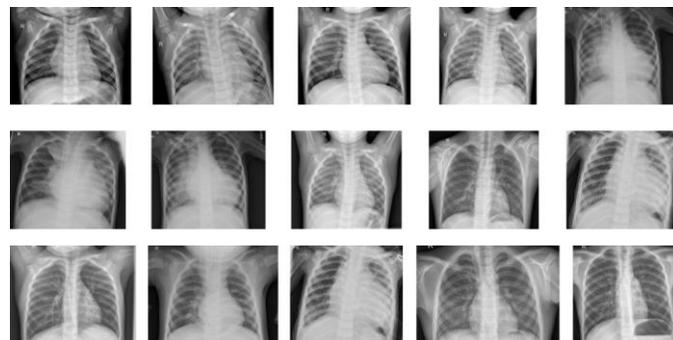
Pneumonia Chest X-ray Database dataset examples
